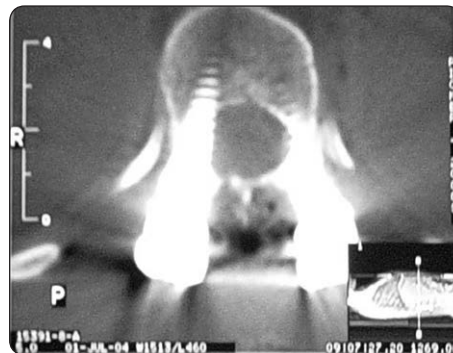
18 years old, Female, Fr. L1, NF. Preoperative plain X-ray anteroposterior (a) and lateral (b) views. Postoperative plain X-ray anteroposterior (c) and lateral (d) views. Postoperative CT scan: upper level (e), fractured level (f), and lower level (g).
